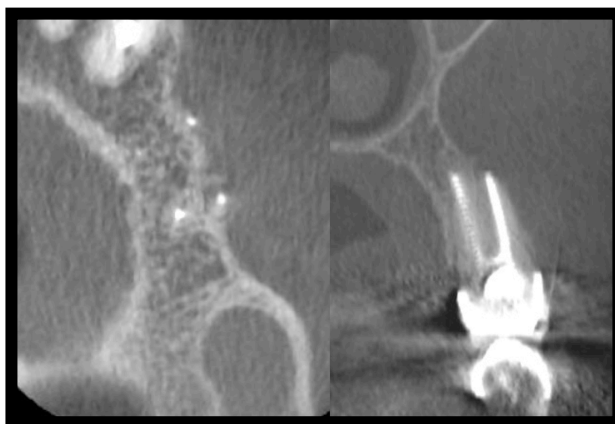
CBCT, 06. Des 2011. Imaging done by department for Oral and Maxillofacial Radiology, University of Oslo
